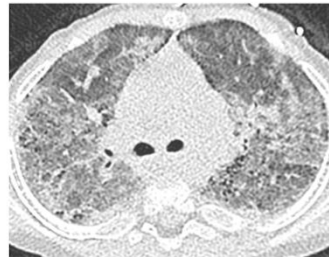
Chest CT and pathological images for historical controls.
